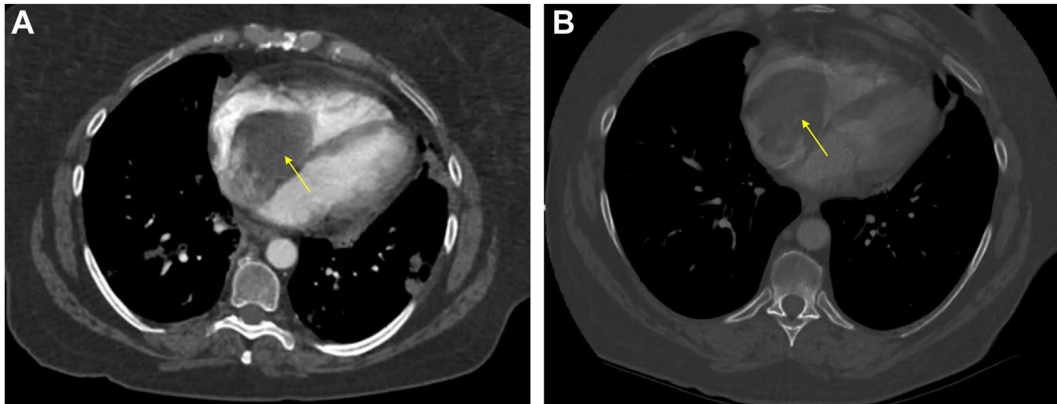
Chest CT (axial view, soft tissue window), at baseline (A) and 3 months later (B) showing very little change in the appearance of the 6.0 cm RA mass (arrow) and interval new small pericardial effusion.
